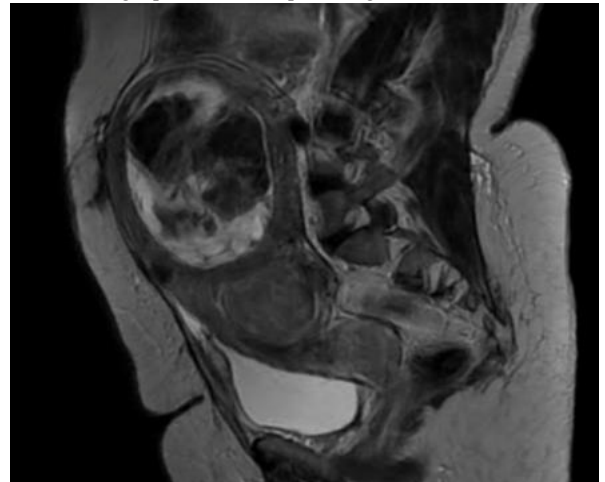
1 MRI of Leiomyoma with degenerative changes.
